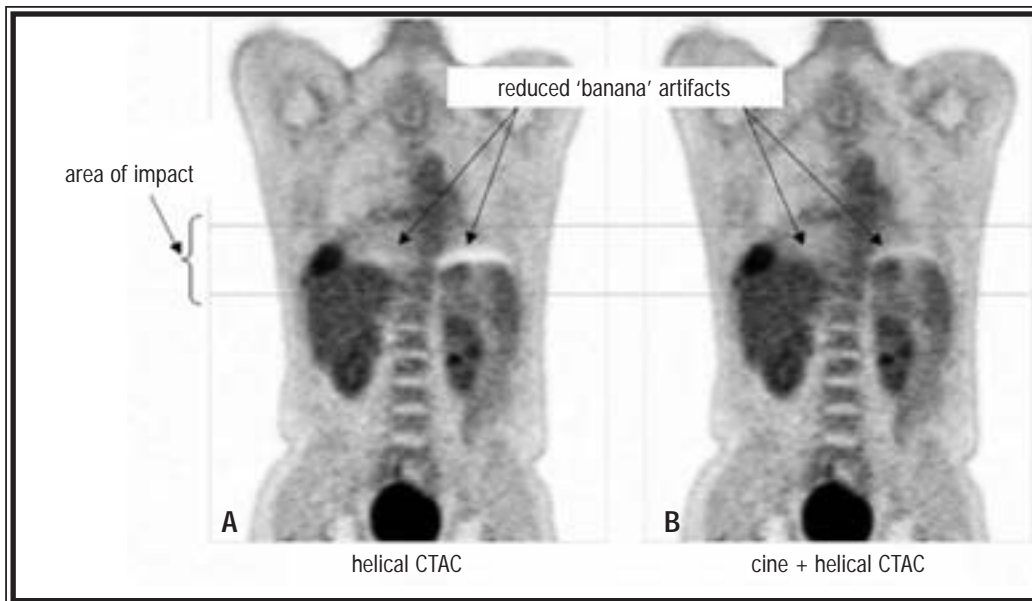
Banana artifacts arise from respiratory mismatch of emission (PET) data and CT attenuation correction images. Image on left is typical of artifacts that occur when a single helical scan is used for CT-based attenuation correction. Image on right demonstrates the significant reduction in banana artifact that can be obtained when a series of cine CT scans over the diaphragm region are added to provide a respiratory-averaged CT scan, similar to that shown in Figure 1D.
